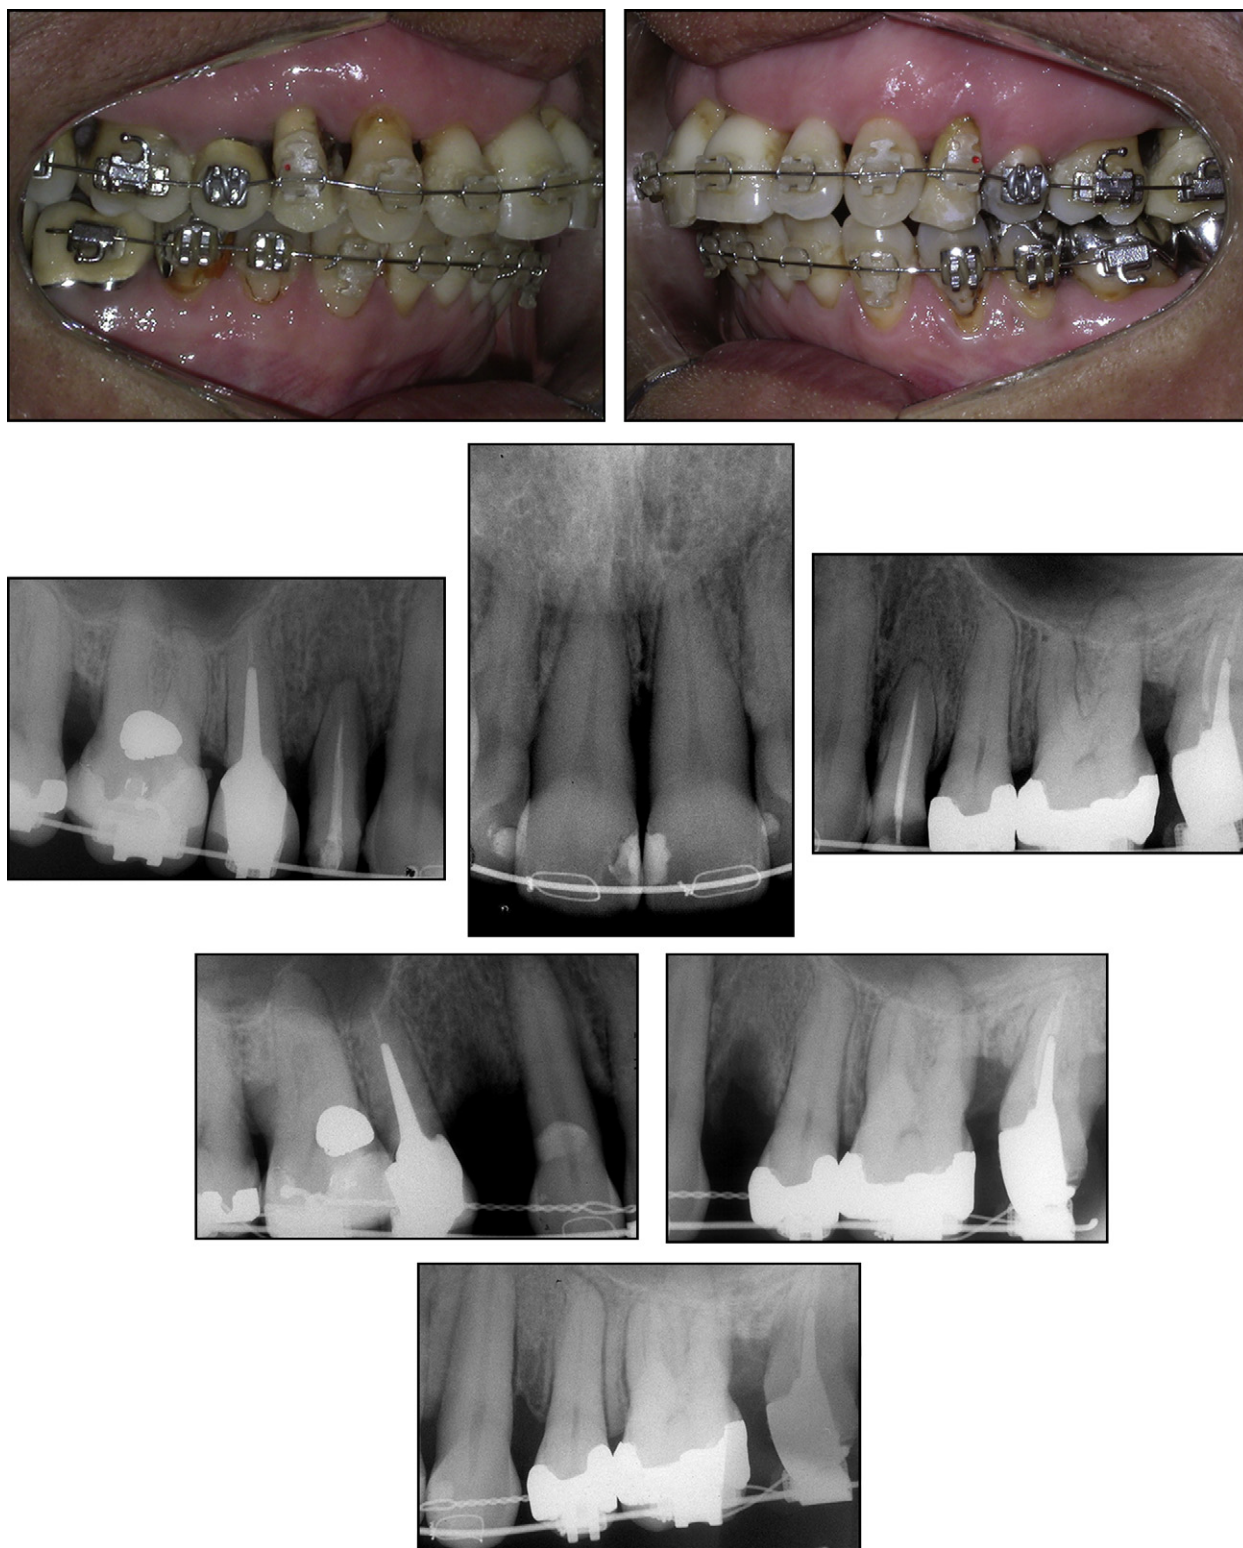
Intraoral progress photographs and periapical radiographs to show bone topography on maxillary premolars.
